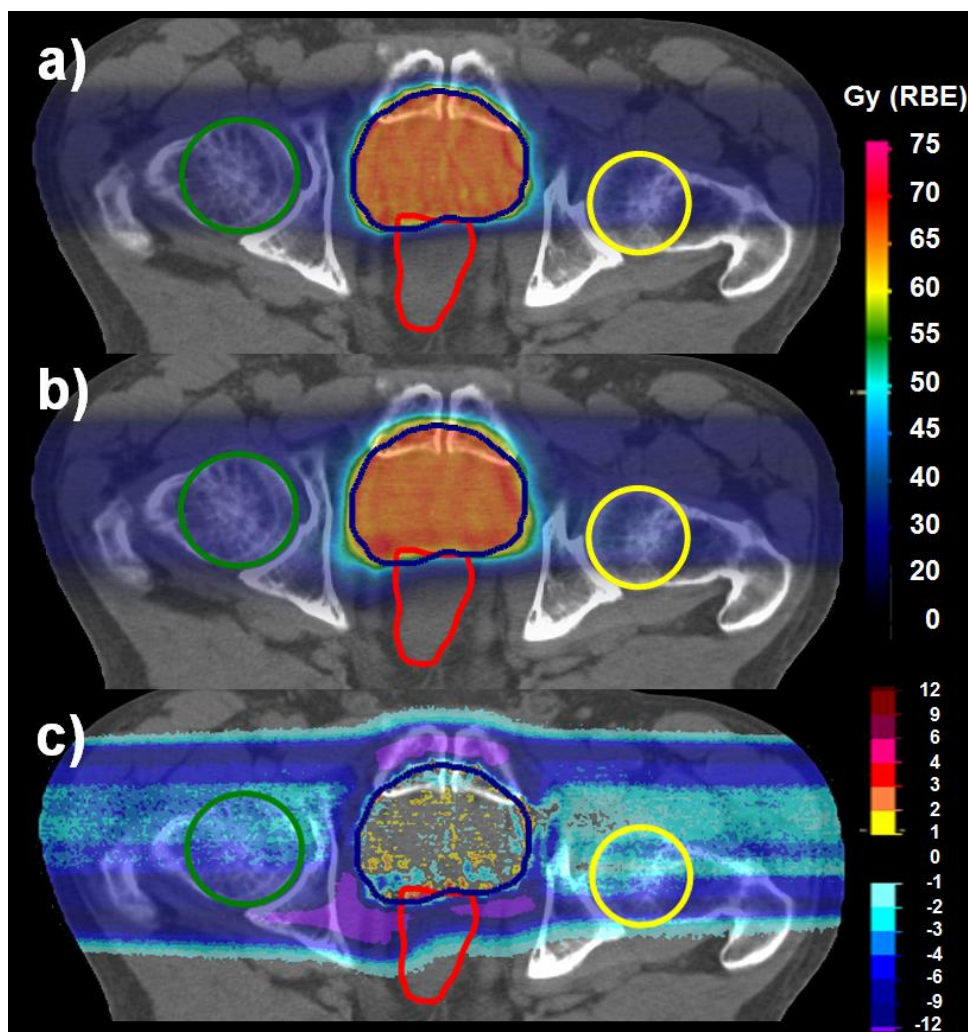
Dose distributions superimposed onto the X-ray CT are shown for patient E, with helium ions on the top panel and protons in the middle panels for an axial slice, centered on the PTV. The bottom panels display the dose difference between the helium ions and proton dose predictions. (Displayed in *RayStation* (RaySearch Laboratories))
